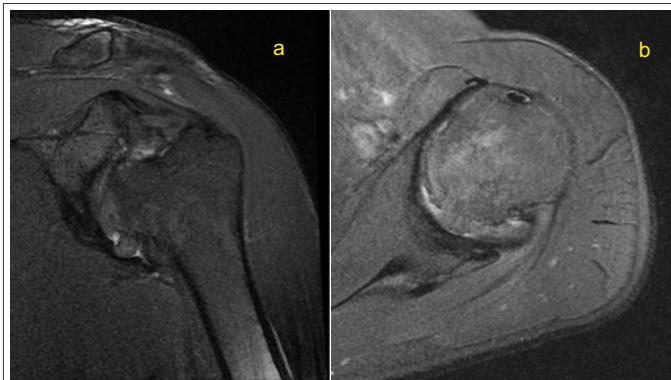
(a & b): MRI scan showing anteroinferior dislocation with intact rotator cuff muscles
